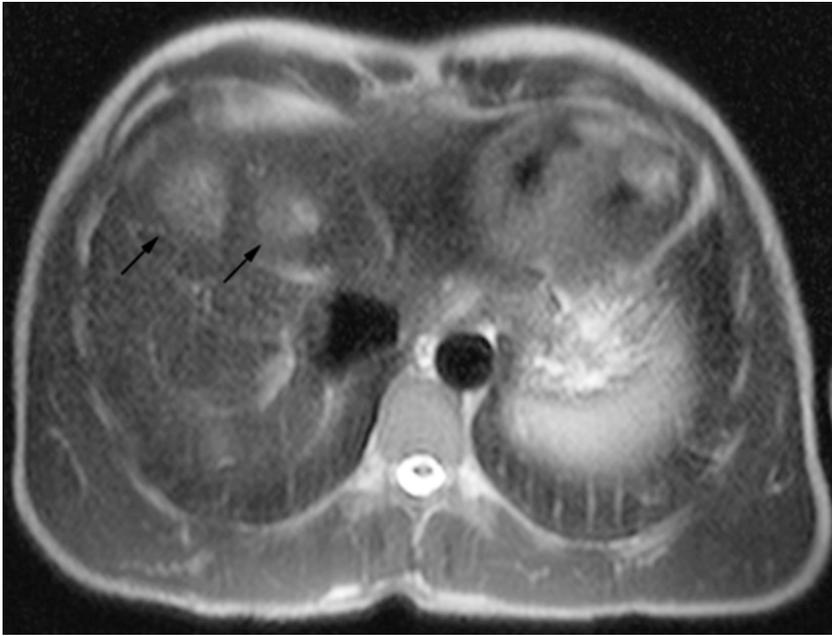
MRI of the liver shows multiple small nodular lesions (*arrows*) that are hyperintense on T2-weighted images.
